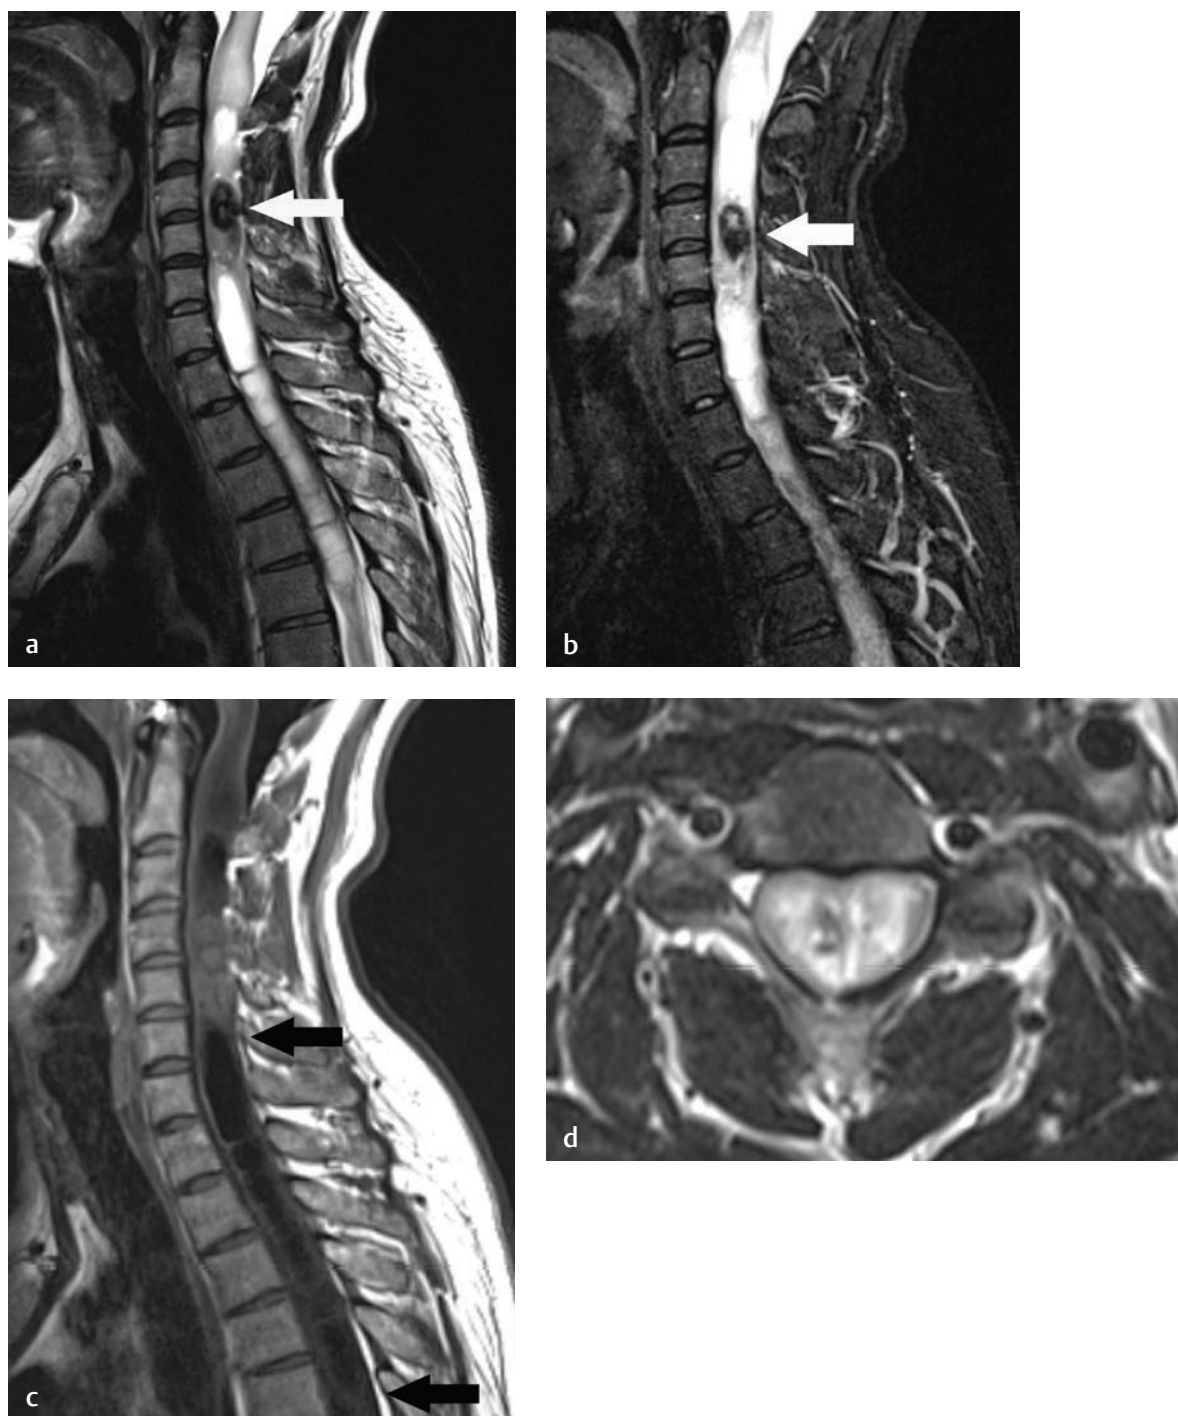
Cervical ependymoma. Sagittal (a) T2-weighted and (b) STIR images show a large cervical ependymoma centered at C4-C5 but with abnormal cord signal extending from C2-C7. Note the hypointense hemosiderin “cap” (arrows on each). (c) A sagittal T1-weighted image shows that the tumor is located at C4-C5 and that the abnormal cord signal change extending below the lesion is secondary to the formation of a septated syrinx (between arrows). A syrinx also extends cranially from the lesion. (d) An axial T2-weighted image shows that the lesion is located within the spinal cord, which is seen as a thin sliver of low signal intensity surrounding the lesion.
